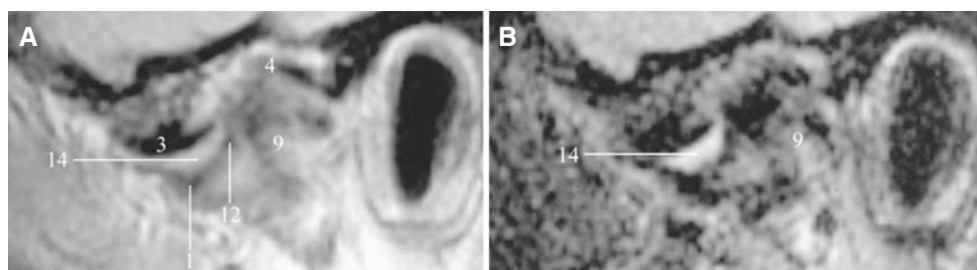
Joint fluid, asymptomatic volunteer. (A) Oblique sagittal T1-weighted and (B) oblique sagittal T2-weighted MRI show increased signal intensity from upper joint space of anterior recess on T2-weighted image (reproduced with permission from Larheim et al. 2001b)
